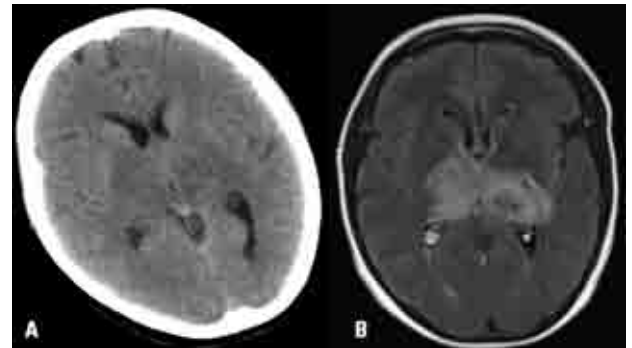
Capsular and thalamic symmetrical hypodensities on CT and MRI.
